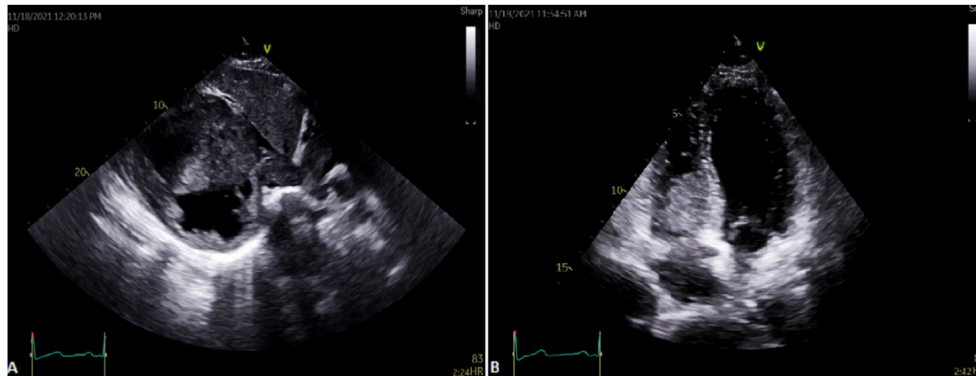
A transthoracic echocardiography (TTE) showing (A) a subcostal view with tumor extension into the right atrium with clear extension through the IVC (B) Apical four chamber view showing a mass extension into the base of the right ventricle.
